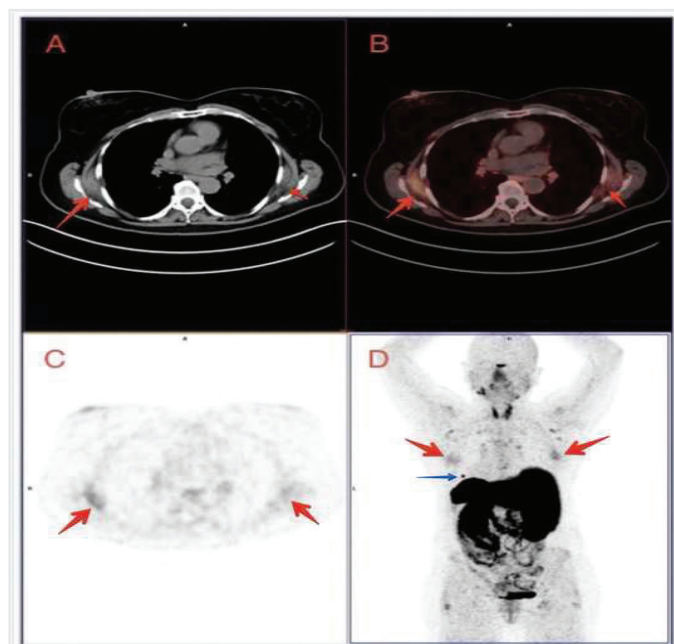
Axial slices of computed tomography (CT) (A), fusion (B), positron emission tomography (PET) (C) and posterior projection of MIP (D) images of a 59-year-old woman with Ga-68 DOTATATE PET/CT examination who was operated for rectal neuroendocrine neoplasia. Ga-68 DOTATATE PET/CT revealed poorly circumscribed, soft-tissue lesions with minimally fat strands (A) and showing increased SSTR expression (B and C), correspondent with elastofibroma dorsi. Right-sided ED is slightly larger than the left one and measures 28x42 mm and SUV_{max} value was 4.21. Also, focal Ga-68 DOTATATE uptake corresponding with accessory spleen (blue arrow) is noted on MIP image
